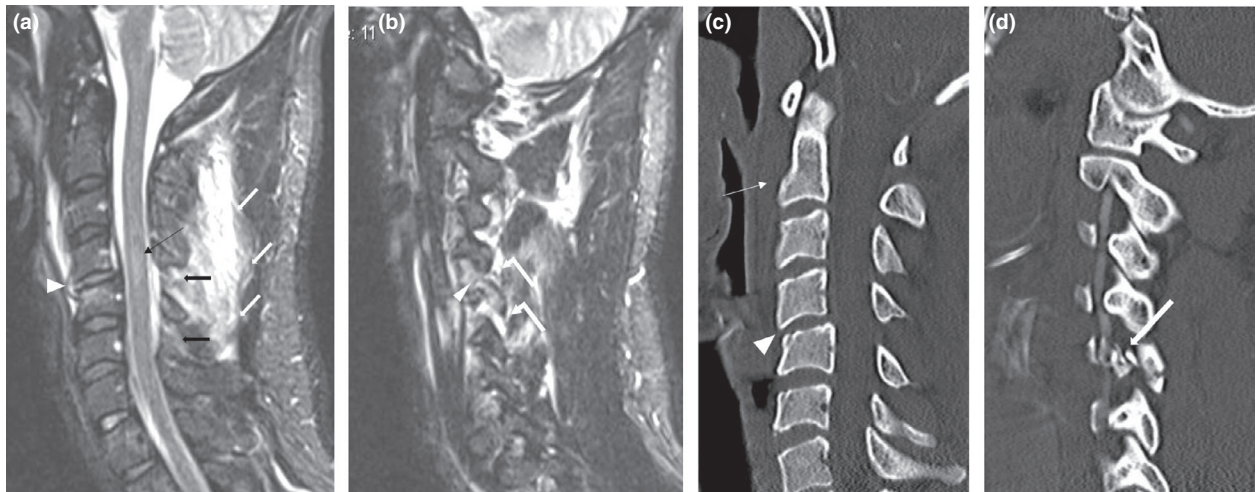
Mixed rotation injury in a 27-year-old man. (a) Mid-sagittal STIR MR image show C4/5 ALL tear (white arrowhead), C4/5 and C5/6 interspinous (black arrows), C2-7 supraspinous (white arrows) ligamentous injury, and a focal cord contusion at C4/5 level (thin black arrow). (b) Left parasagittal STIR MR image shows extensive hyperintense signal in the C4/5, C5/6 facet capsules (bent arrows) and left C5 articular process and concomitant laminar injury (arrowhead). Facet joint capsular injuries are best seen on axial or sagittal images and present as STIR hyperintensity, >2mm widening or dislocation. Rotational injuries usually result in facet injuries and are often associated with posterior ligamentous and cord injuries. (c) Mid-sagittal and (d) Left parasagittal CT images show prevertebral soft tissue widening (thin white arrow), C4/5 disc narrowing and mild anterior subluxation (white arrowhead) and left pedicle, lamina and inferior facet process fractures (solid white arrow).
